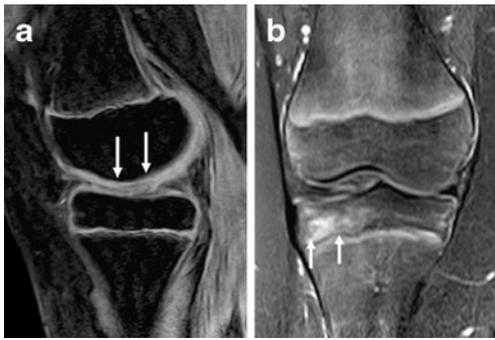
Sagittal 3D WATS (a) and coronal PD TSE SPIR (b) MRI of an 11-year-old young boy suffering from pain in his right knee with no trauma. The patient is classified as morbidly obese with a height of 152 cm, a weight of 66 kg, exceeding a BMI of 28.6 kg/m^2 . Range of motion of the young patient is 0-0-145. In a the cartilage lesion grade 1–2 according to Outerbridge in the medial compartment is seen (white arrows). In b the knee shows a marked bone bruise area in the lateral tibial region predominantly (white arrows)
